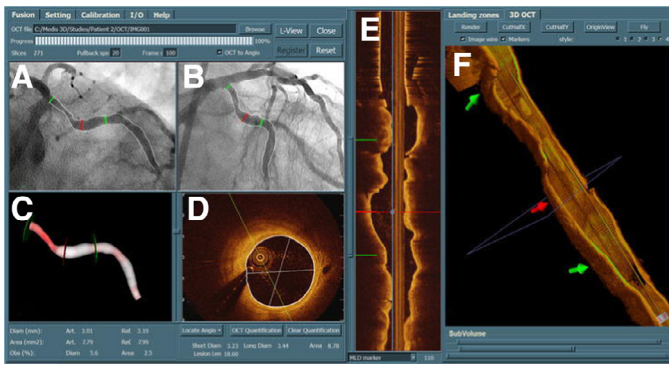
Fusion of X-ray coronary angiography with OCT: Corresponding locations are shown with the same colors in different views. Fusion provides clinician with complementary information from both modalities for the assessment of vessel lumen. Reprinted from Tu et al. (2012) with permission from authors.
